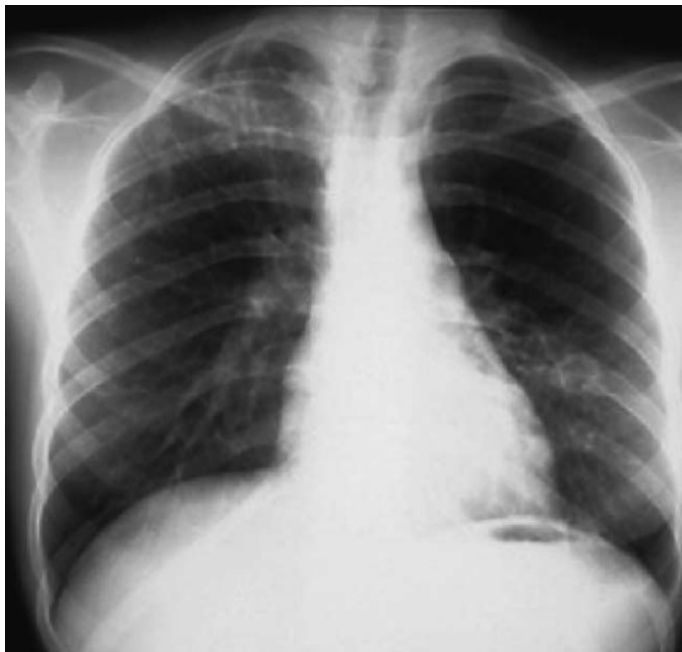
Post-primary TB chest radiography. Multiple involvements, infiltrates in the right upper lobe, cavity present in left lung lingula. Adapted from Andreu *et al.*, 2004 (25).
